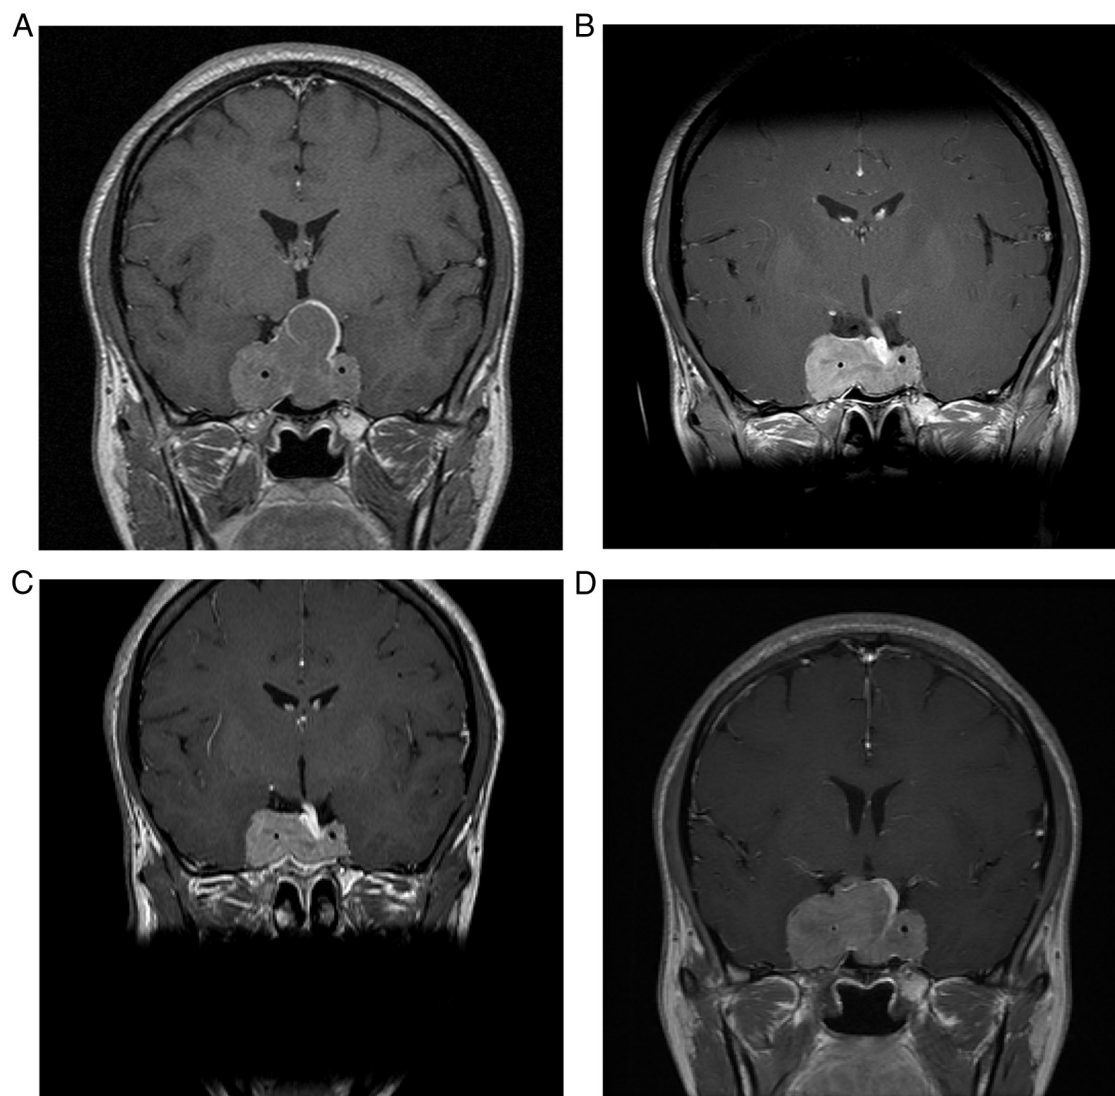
Magnetic resonance images of first patient (tumor growth). A, At diagnosis. B, Three months after the first surgery, no medical treatment. C, Eight months after the first surgery, Sandostatin LAR 20 mg every 4 weeks. D, Seven months after the addition of PEGV, Sandostatin LAR 30 mg every 4 weeks + PEGV 160 mg weekly.
